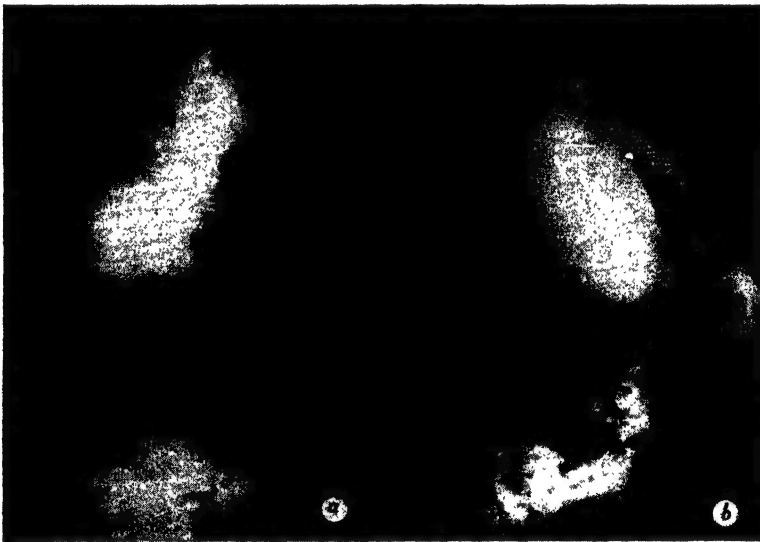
“Secondary” Pellagra conditioned by Cardiospasm. Anterior and lateral views of X-ray after swallowing barium meal, showing enormously dilated and tortuous oesophagus with a constriction in the middle third. Same case as Fig. 82.
